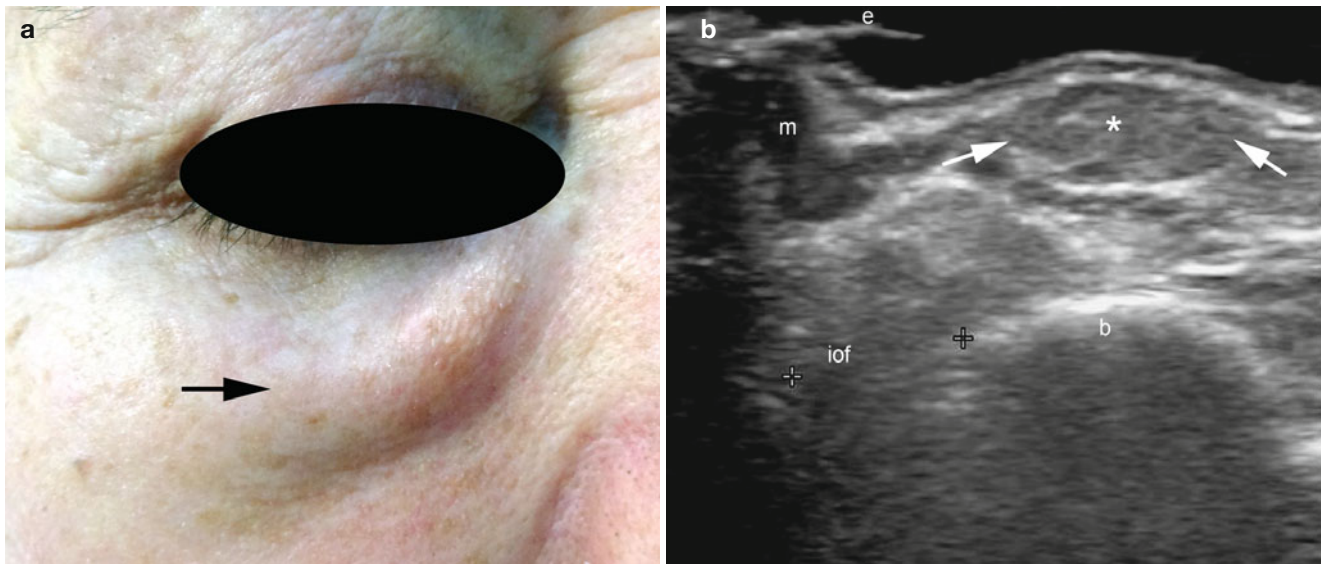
(a, b) Autologous harvested fat. (a) Clinical image shows swelling (*arrow*) that appeared in the right lower eyelid after transfer of autologous harvested fat. (b) Grey scale ultrasound image demonstrates
